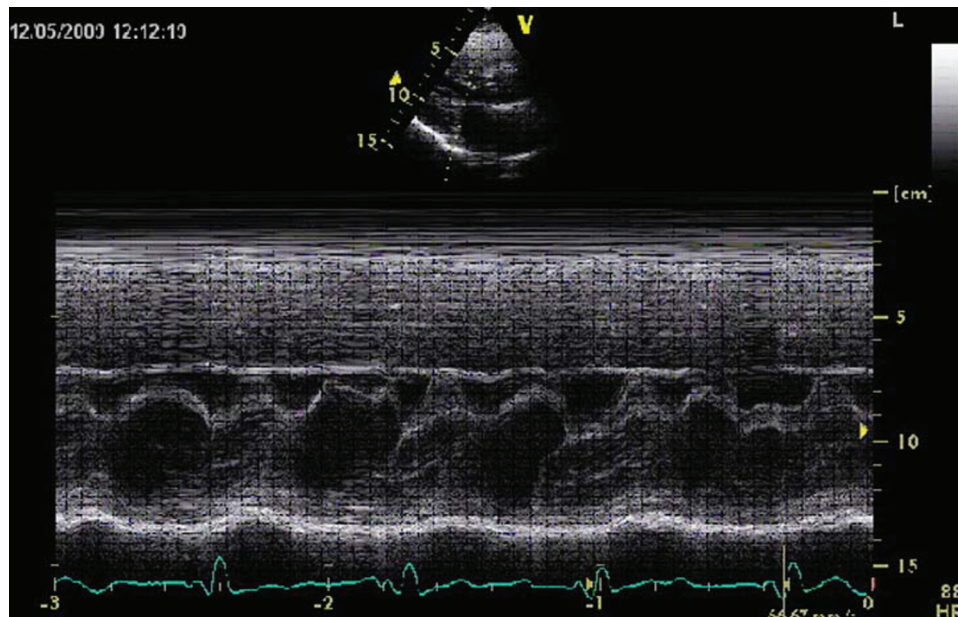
M-mode Doppler showing classical systolic anterior motion of the mitral valve prior to right ventricular pacing.
